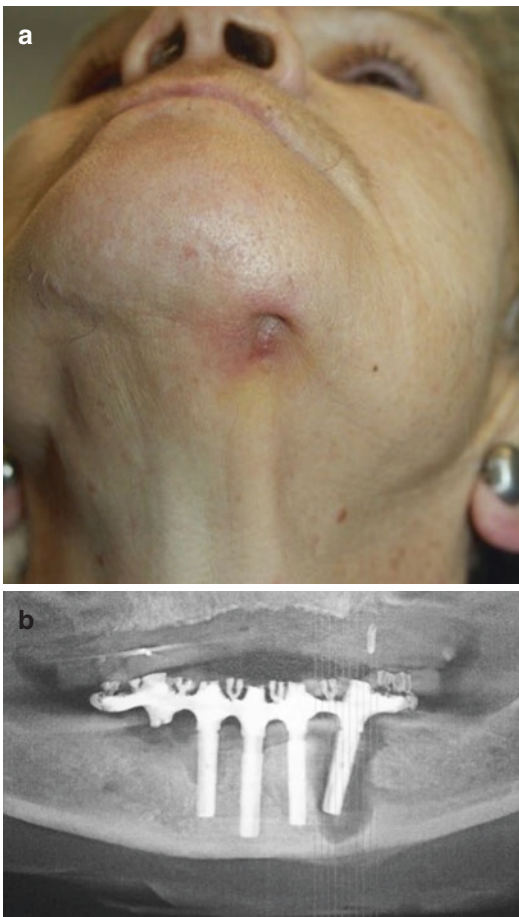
(a) Untreated peri-implantitis surrounding the entire implant is causing an external fistula to drain the infection. Once the osteointegration of the implant is lost, it becomes a corpus alienum. (b) Panoramic radiograph
